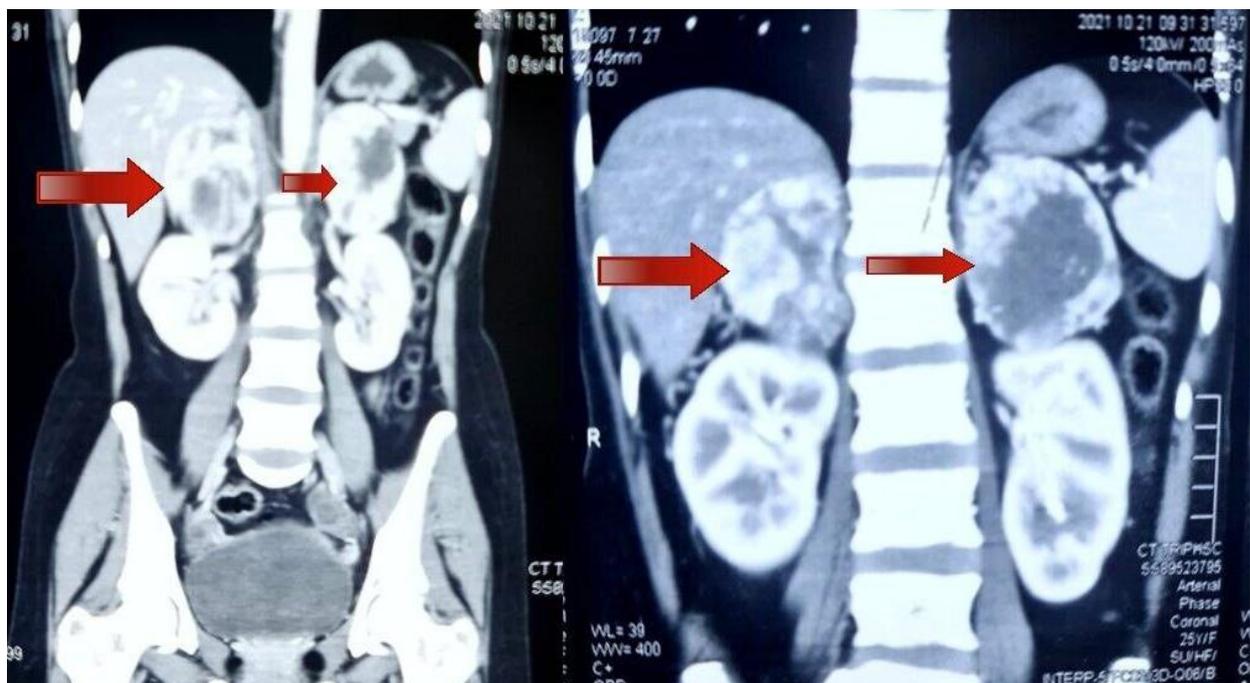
CT Abdomen and Pelvis showing Bilateral Adrenal Masses
